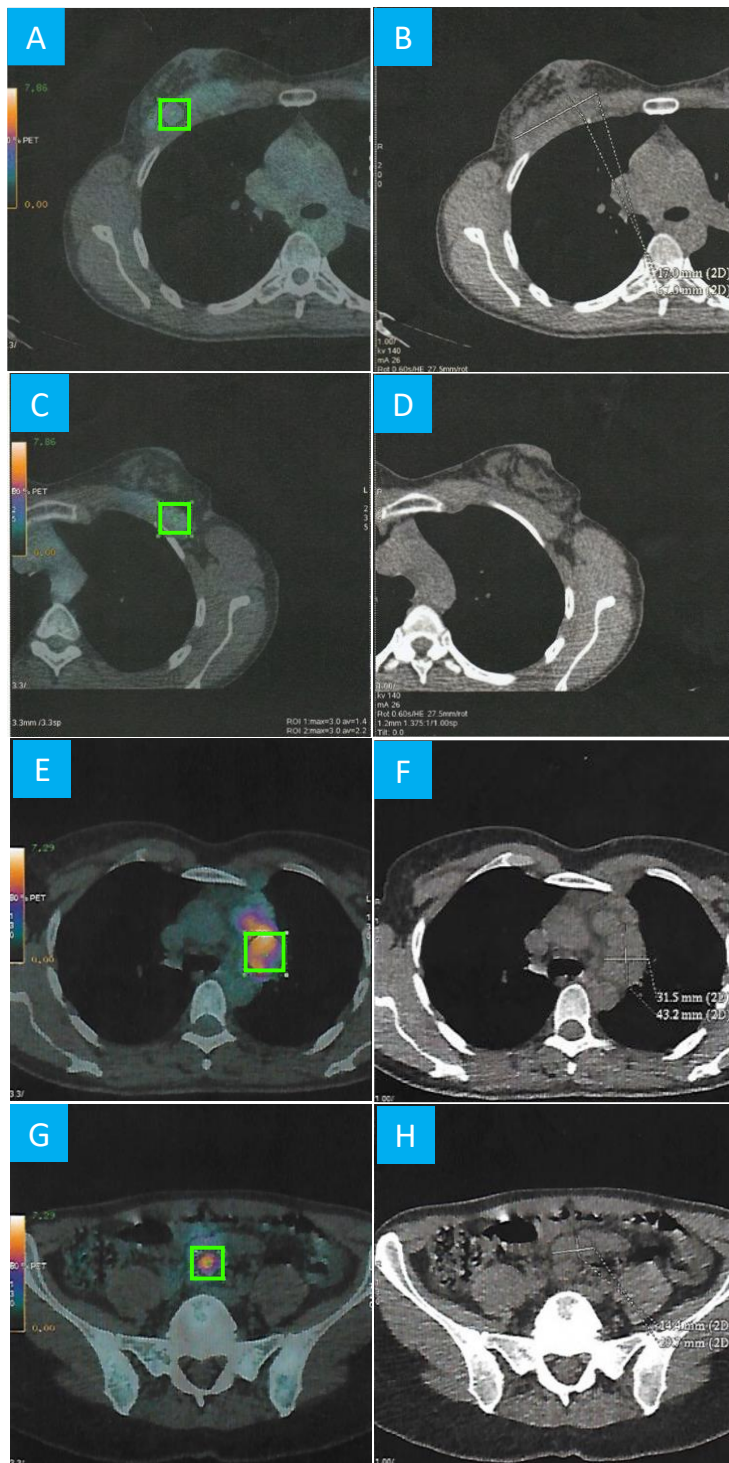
A, C, E, G (left column): combined PET-CT scans with metabolically active foci (marked green). B, D, F, H (right column): CT scans of lymphoma infiltrated nodules. A–B – Patient 2 PET-CT scan. At the border of the right glandular tissue of the breast and pectoral muscles visible lymphoma infiltrations 67.0 x 17.0 mm (SUVmax = 3.0). C–D Left pectoral
